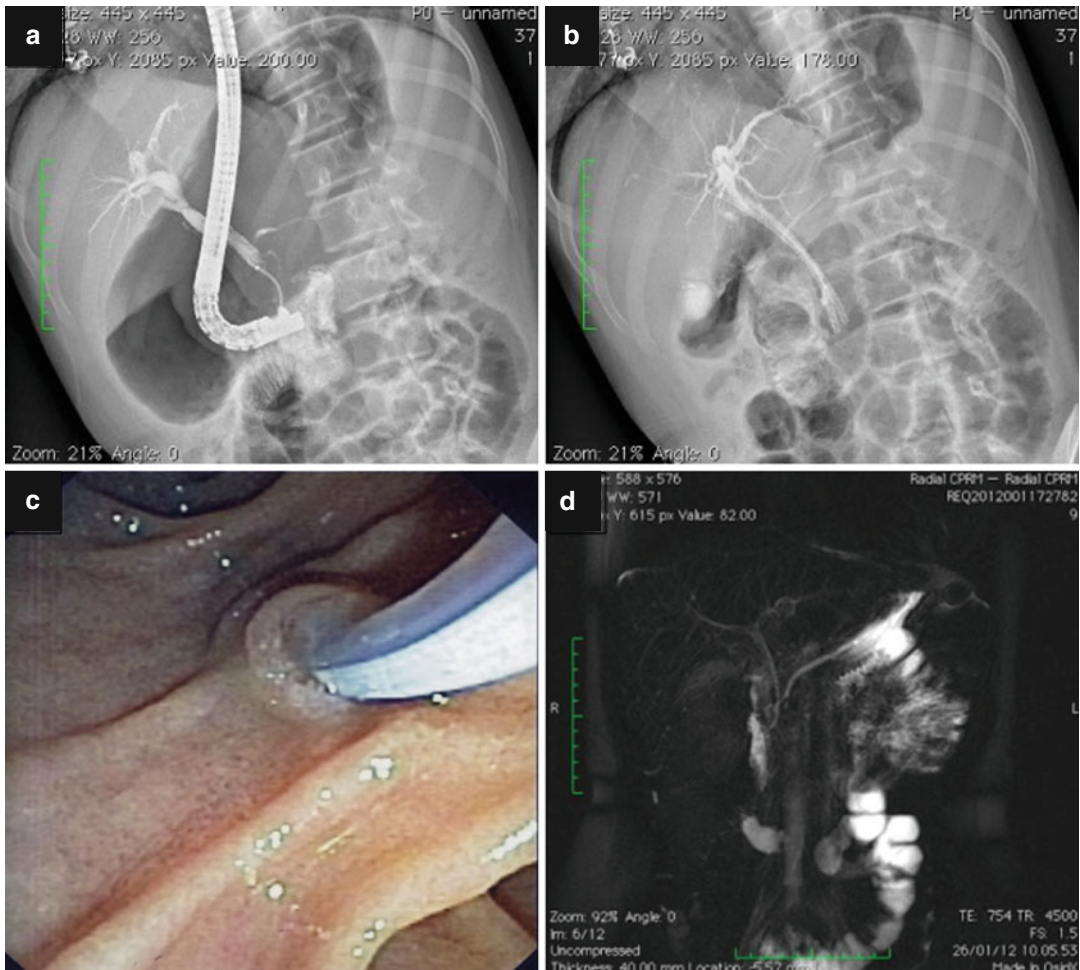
Radiological (a, b) endoscopic (c) and MRI (d) findings of plastic biliary stents placed in a child with chronic pancreatitis associated to jaundice and choledochal dilation
